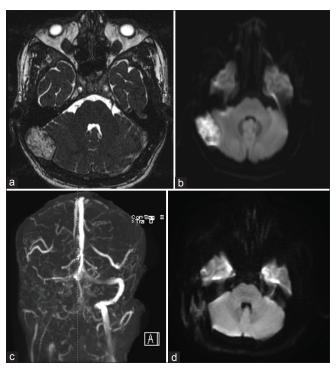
Preoperative (a) T2 magnetic resonance imaging (MRI), (b) diffusion-weighted imaging (DWI) MRI, and (c) magnetic resonance venography demonstrating right posterior fossa mass causing transverse sigmoid sinus occlusion with cerebellar distortion. (d) Postoperative DWI MRI showing resection of the mass.
